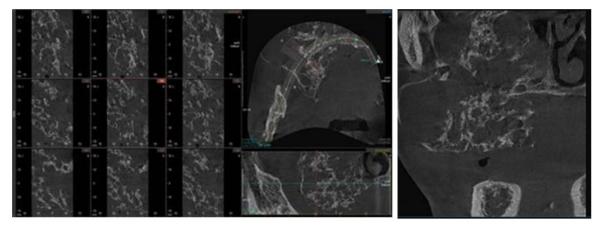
CBCT (coronal and cross-sectional views) showing an expansile lesion with mixed radiopaque—radiolucent internal structure involving the left maxilla and extending inferiorly into the alveolus
